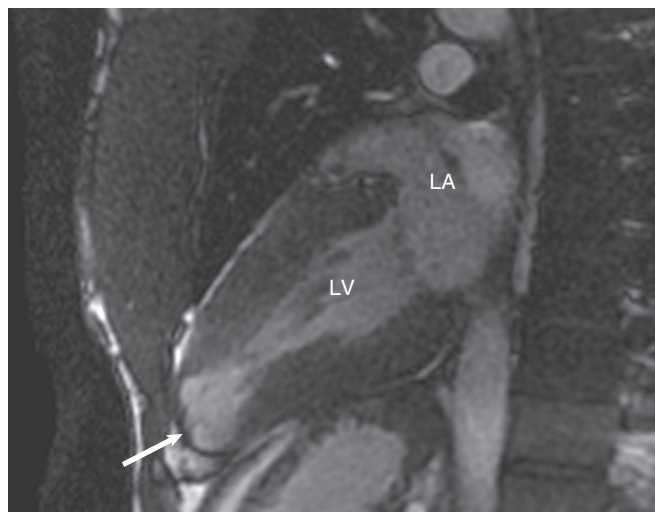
Apical aneurysm in HCM. An apical aneurysm (arrow), which was not visualized on echocardiography, is seen on the CMR image. LA = left atrium; LV = left ventricle.
